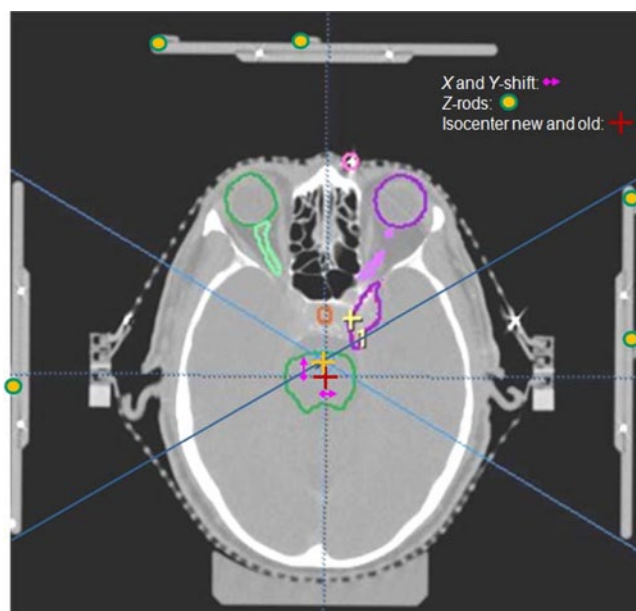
◀ Reconstruction of the new isocentre (yellow) in relation to the reference CT scan (original isocentre in red) by defining the coordination system of the co-registered data set. Measurement of shifts in x and y direction (arrows). Shifts in z direction are measured by defining the rods in the localizer box (green rings)
